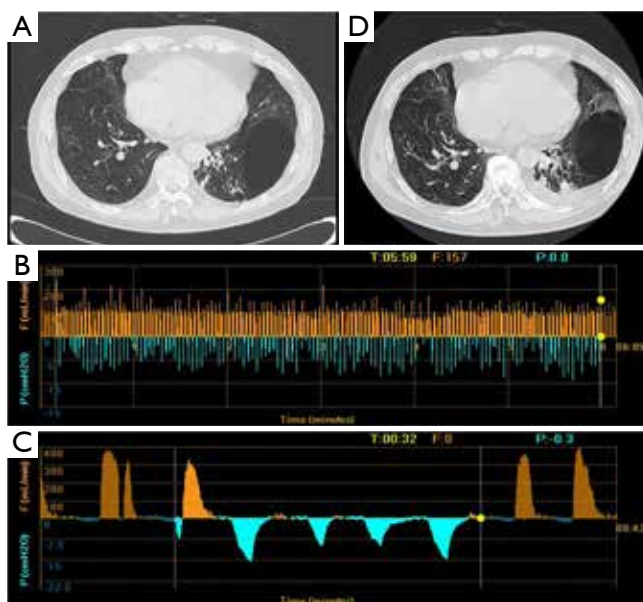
CT imaging and Chartis result of patient 2. (A) A bulla in RUL and severe destruction of lung tissue of RUL; (B) Chartis test showed low flow at RUL; (C) CV was positive as measured by Chartis system at RLL; (D) chest CT did not show reduction of bulla volume at RUL. RUL, right upper lobe; CV, collateral ventilation; RLL, right lower lobe.
